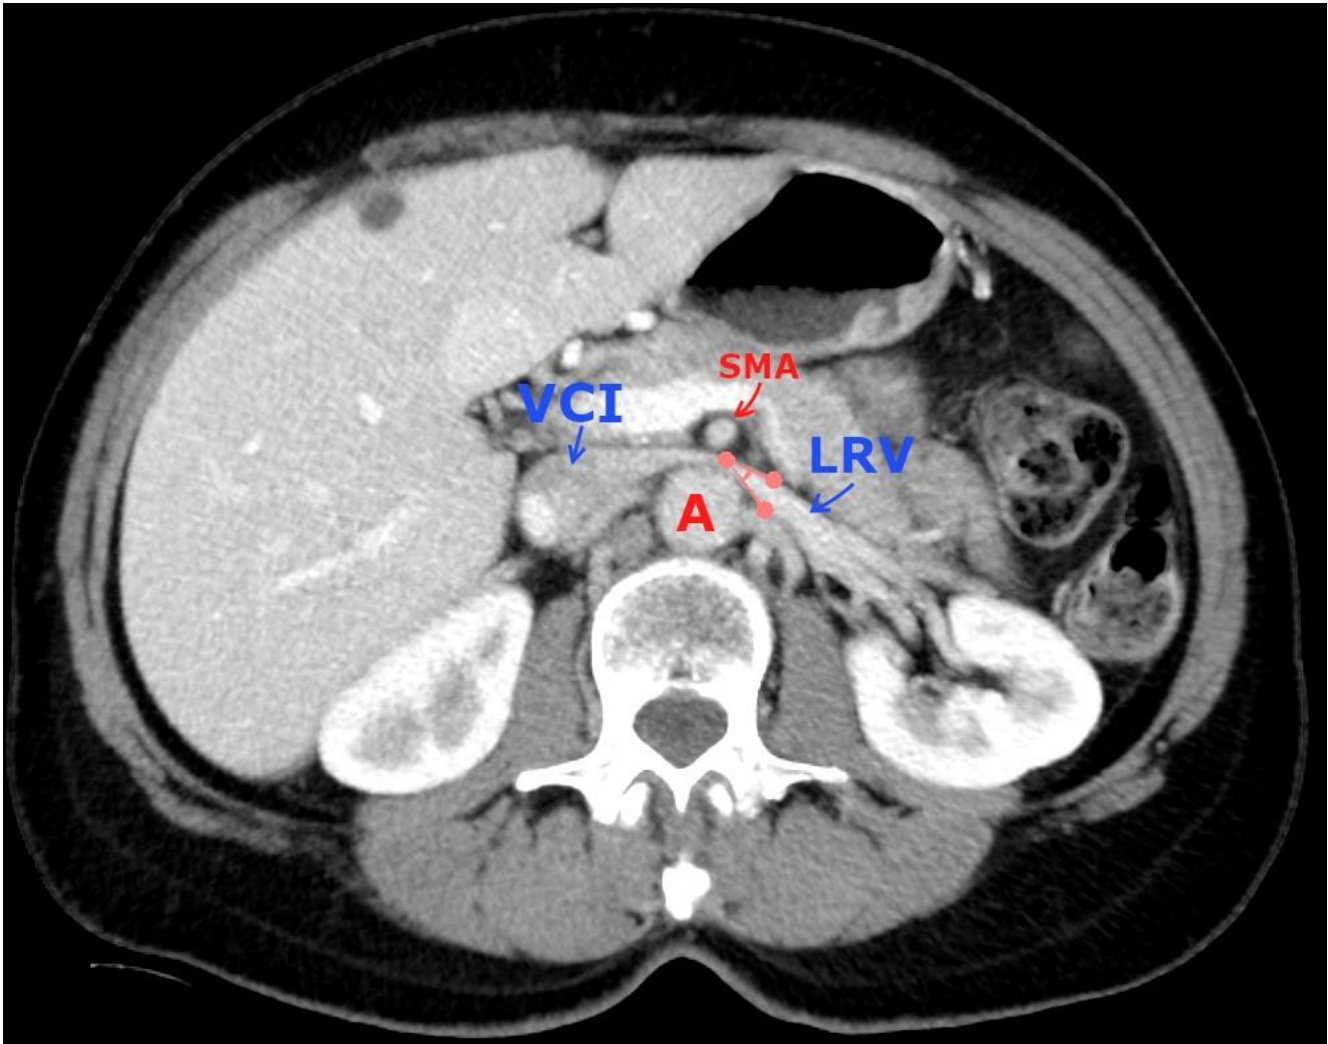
CT axial plane. The structures are labeled as follows: “A”-Aorta, “LRV”-Left Renal Vein, “SMA” – Superior Mesenteric Artery, “IVC”-Inferior Vena Cava. The “beak sign” is also visible (indicated in pink; the angle is approximately 29.5°).
